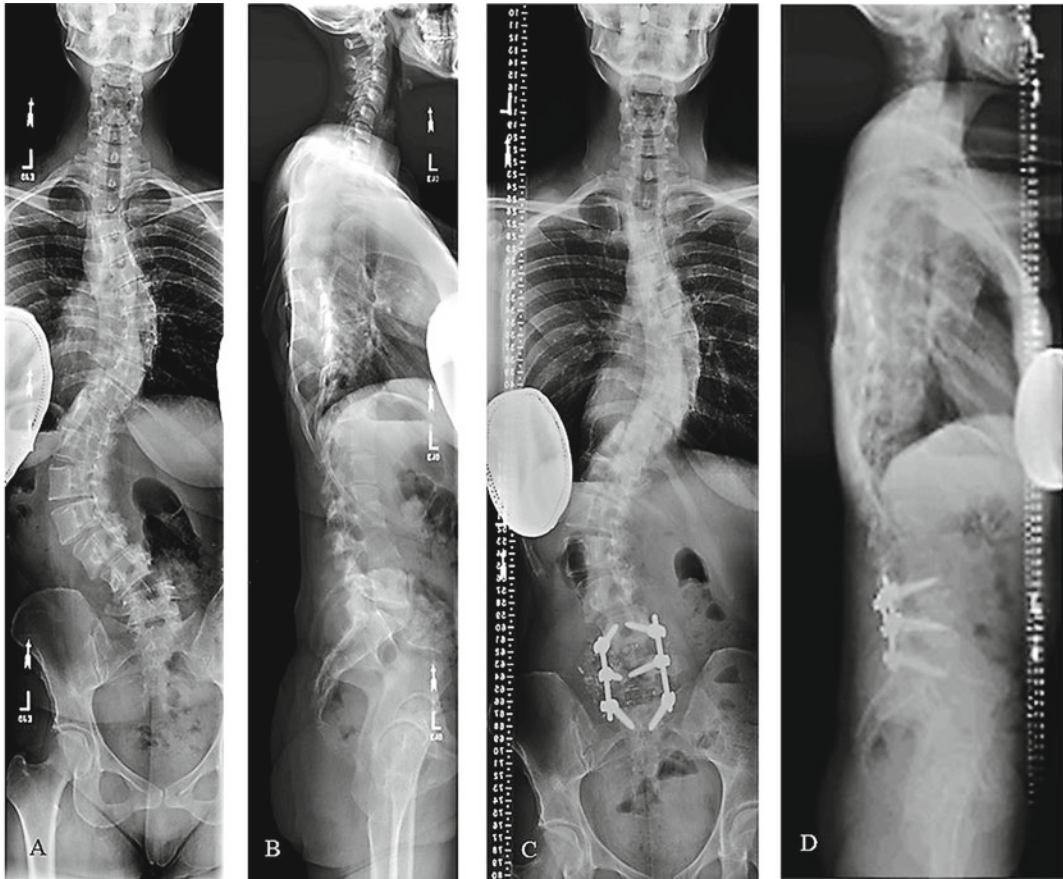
A 32-year-old female with adult idiopathic scoliosis. She presents with limited L4 and L5 radicular pain and significant lumbosacral pain. (a) Preoperative AP scoliosis X-rays. Her deformity has not progressed in the past 8 years. She is well aligned globally in the coronal plane.
